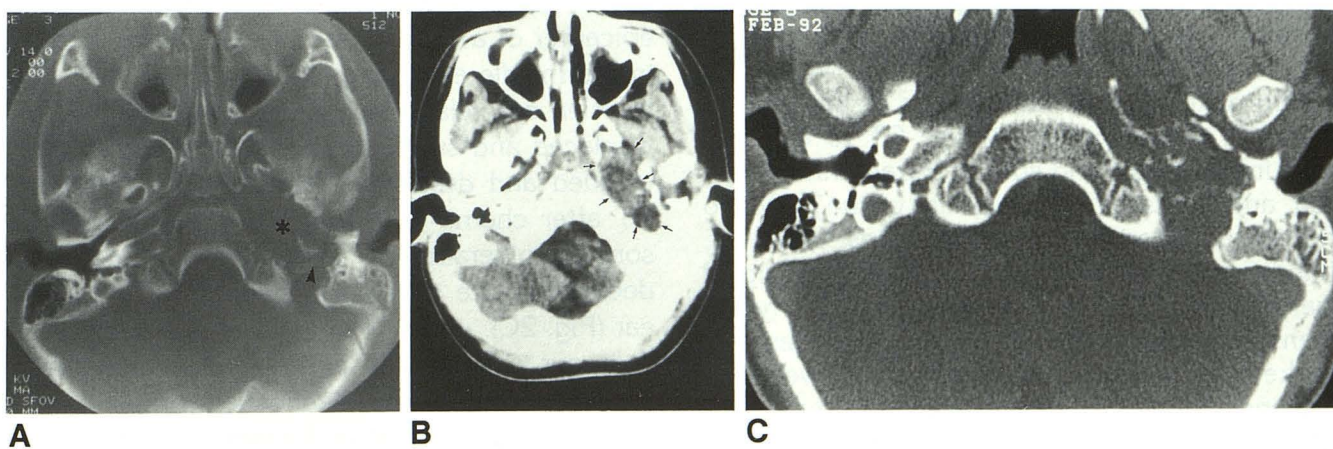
A, Axial CT section (*bone window*) shows destruction of the bone margins of the eustachian tube as well as destruction of the medial petrous bone (\*). The anterior margin of the jugular foramen is eroded (*arrowhead*).
